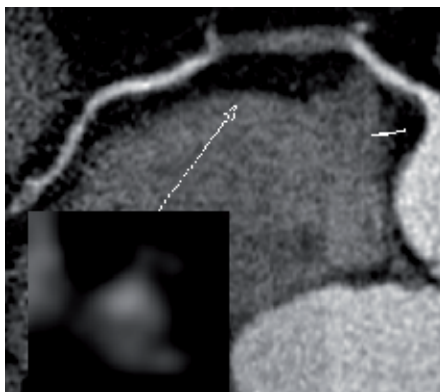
Curved Planar Reformation of the Coronary Artery in CCTA. The curved planar reformatted computed tomography angiography image of the right coronary artery demonstrates two large, predominantly non-calcified atherosclerotic plaques with spotty calcification (arrowheads) in the proximal segment and mild of the right coronary artery.
